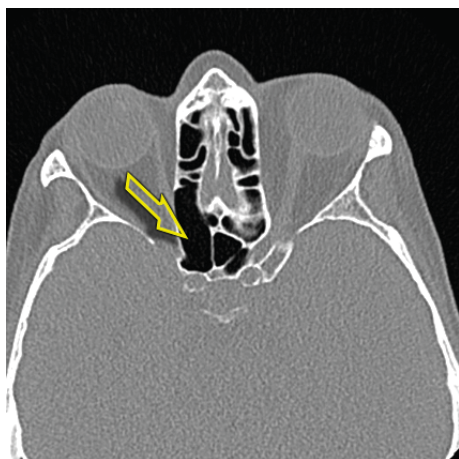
A computed tomography scan of the paranasal sinuses, transverse section. The Onodi cell is marked on the right side.
